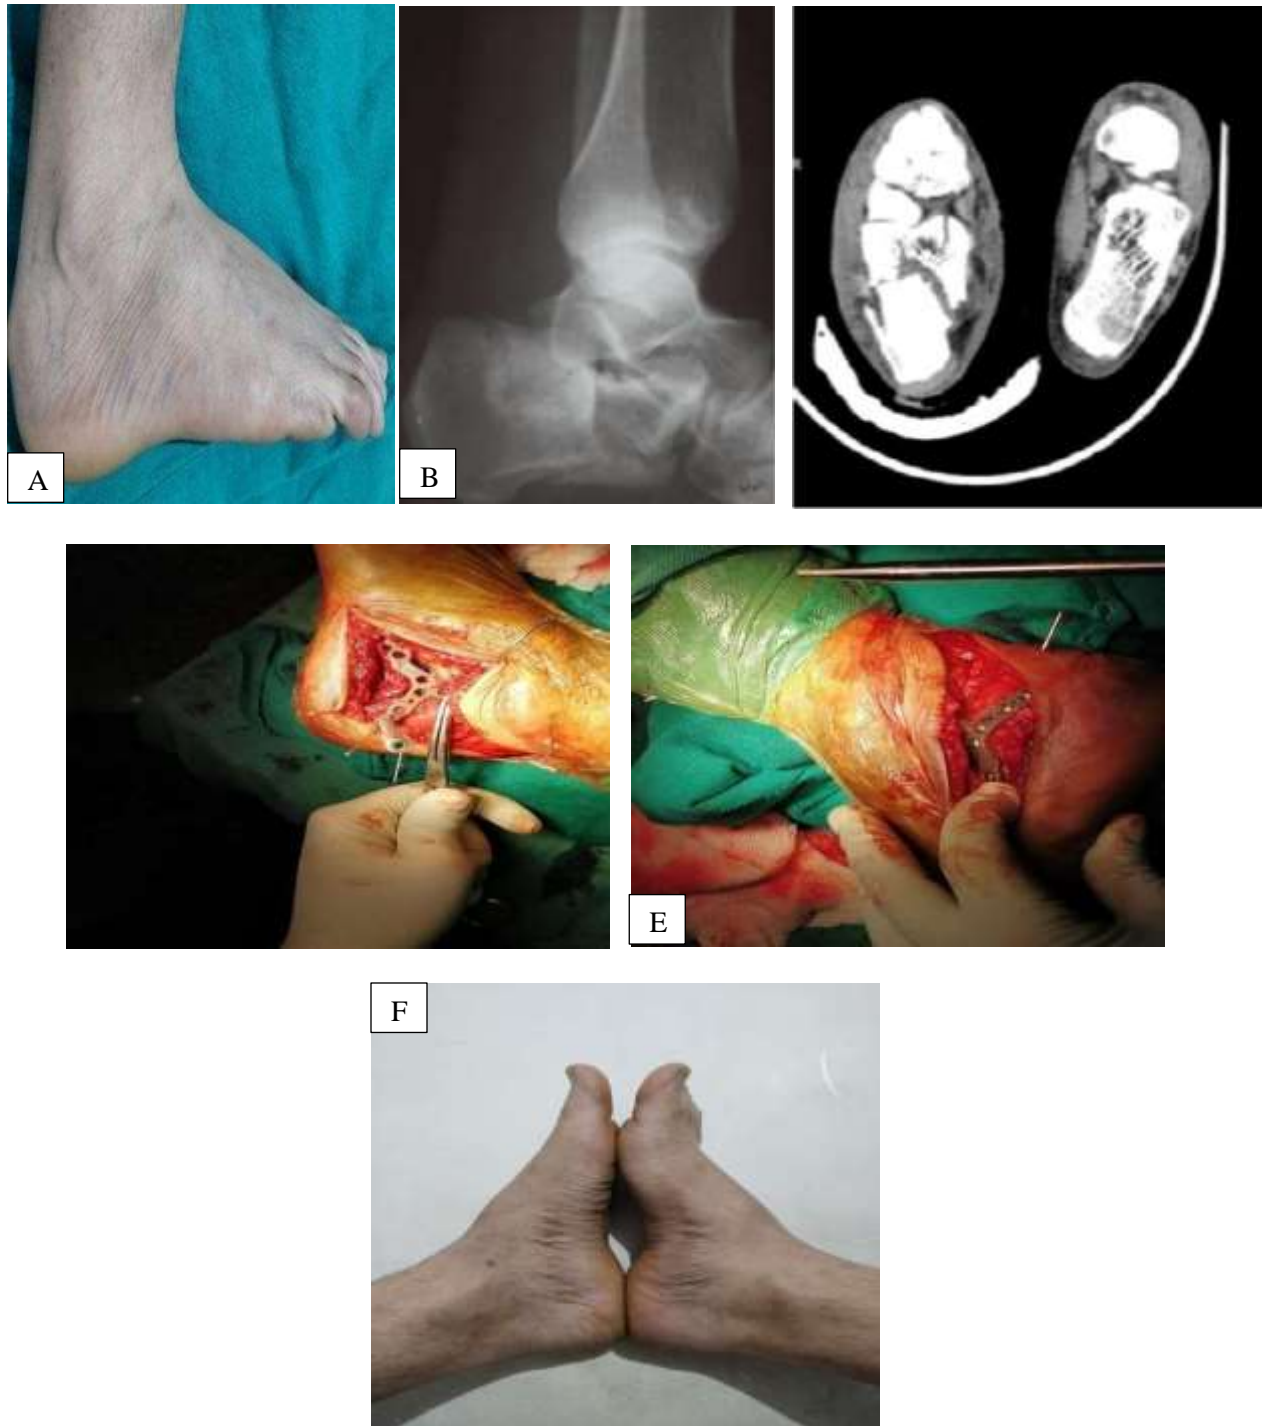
a,b,c,d ,e,f shows the wrinkle sign, preop sanders type 3 , CT scan showing Sanders type III lateral calcaneal approach with application of lateral anatomical plate, fracture reduction process with the use of K-wires, Functional outcome at 9 months follow up.
